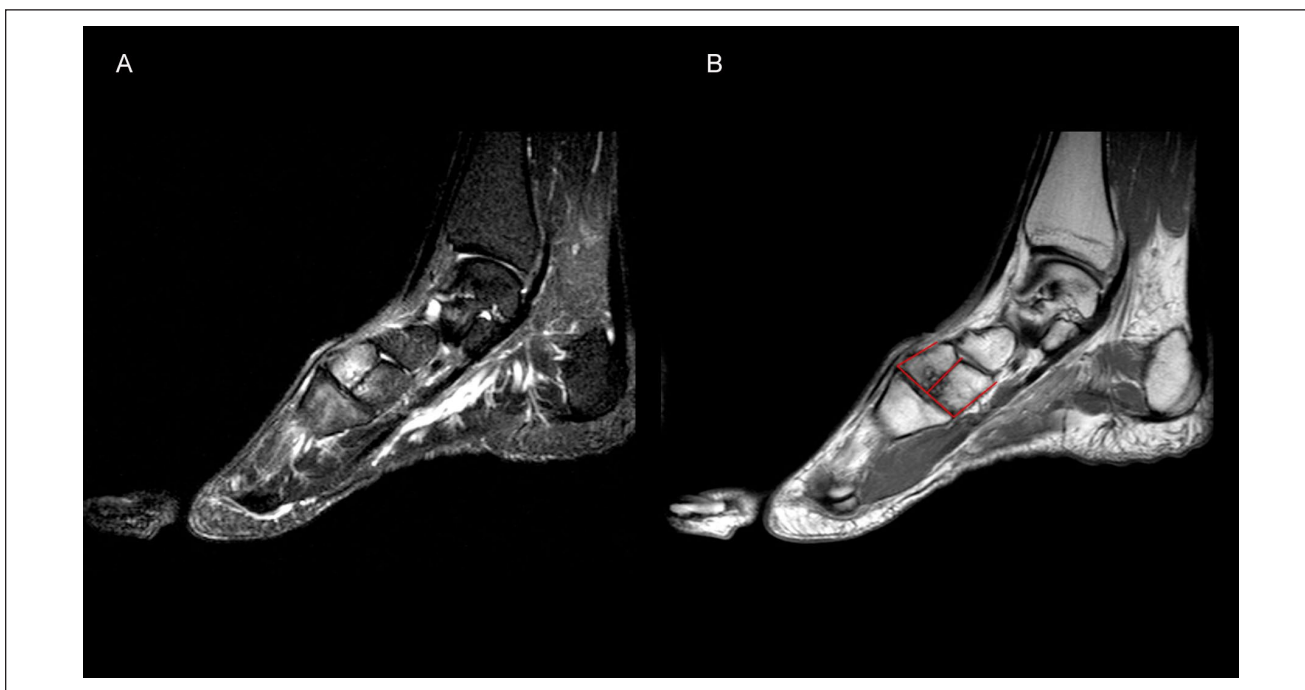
Magnetic resonance imaging showing the presence of bone marrow edema but no diastasis at the synchondrosis of the 2 ossicles in (A) T₂- and (B) T₁-weighted sagittal scans. Joint spaces between the head of the first metatarsal and the distal aspect of the 2 medial bipartite cuneiform bones as well as the horizontal line between the 2 ossicles of the medial cuneiform create a characteristic formation that has previously been described as the “E-sign” (red lines).⁶
